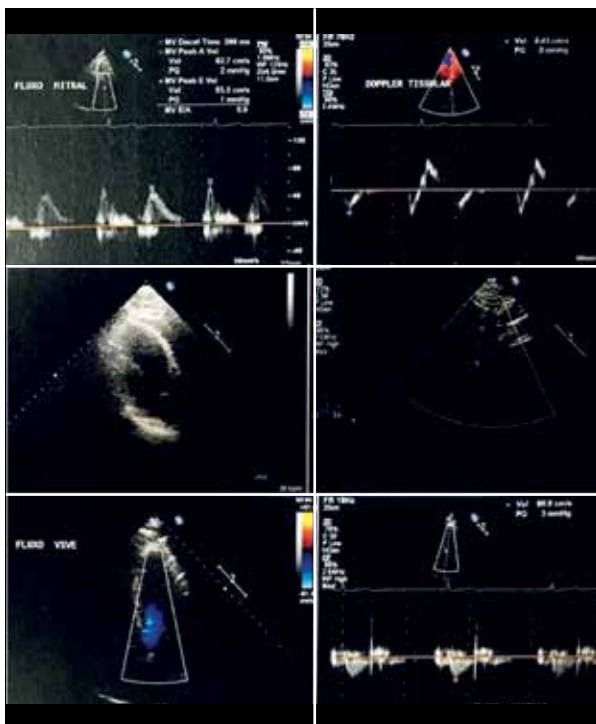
Results of echocardiography performed on December 21, 2016 (78-year-old patient). Information see Table 2.
